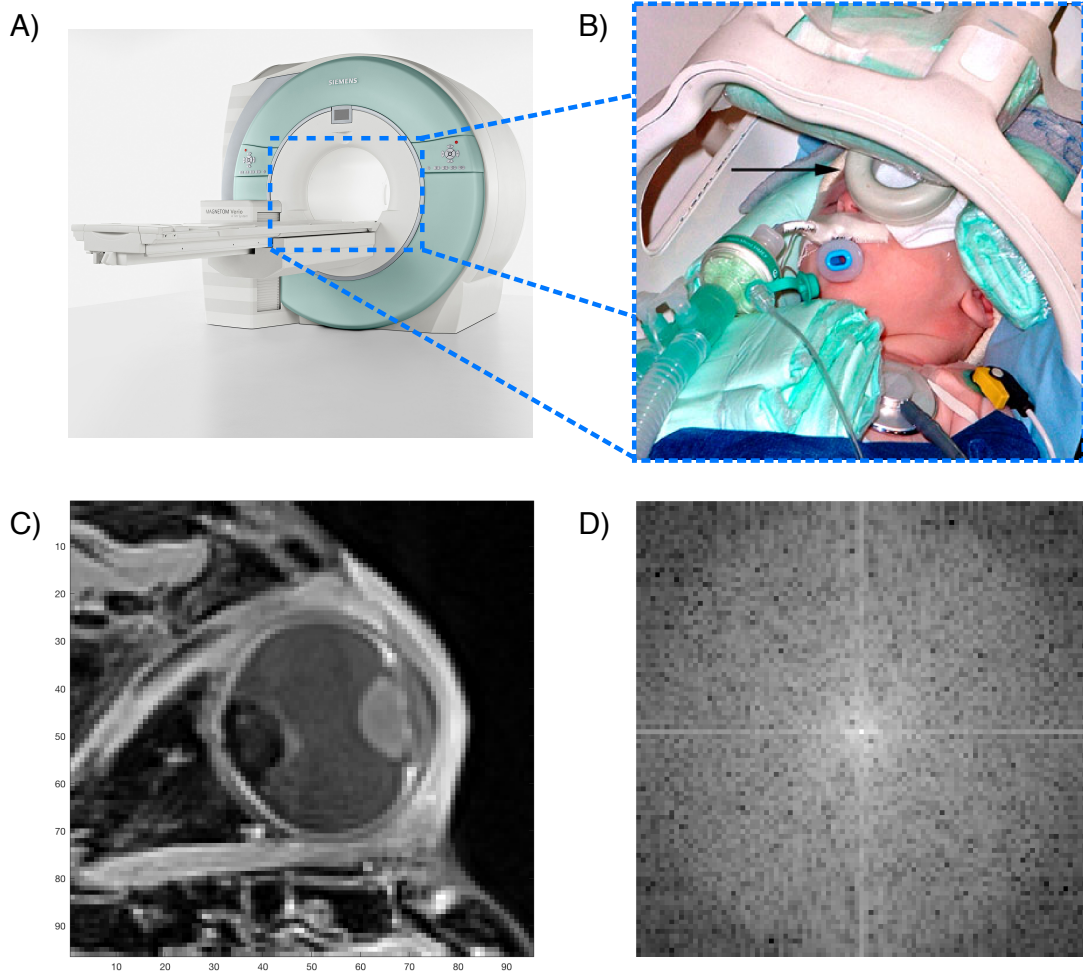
Details of MRI setup for children and example of MRI image in K-space : A-B) General setup for patients with retinoblastoma. C-D) Detail of a T1w VIBE MRI and its k-space representation.
